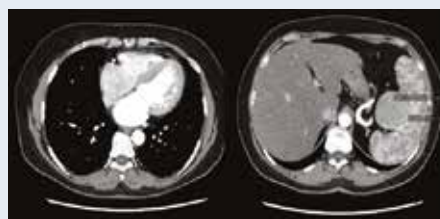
Chest and abdominal computed tomography showed left ventricular concentric hypertrophy and tumour of the spleen with a size of 4.6 × 4.9 cm
